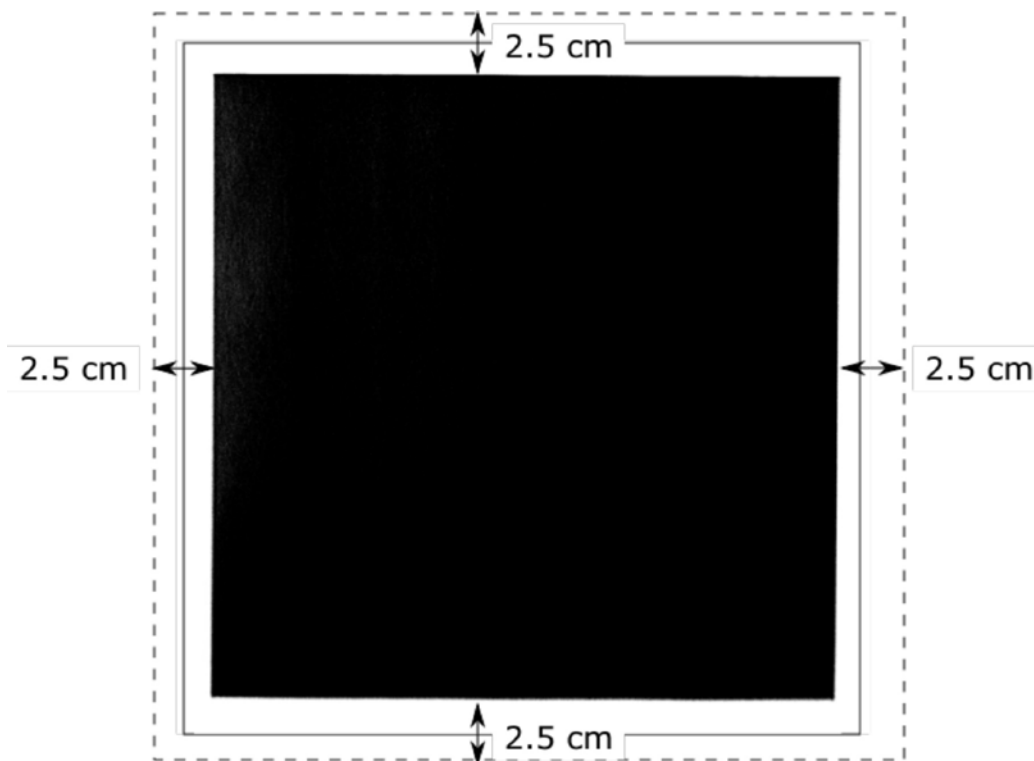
Radiograph showing x-ray field with field size 5 cm smaller than maximum value. The dotted line represents the maximum size of the radiation field allowed by the PBL; the solid square is the outline of the image receptor.
